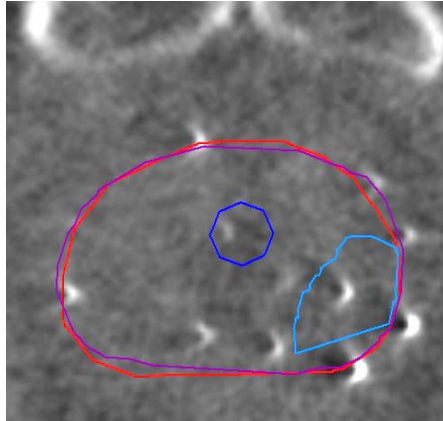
Boost₁ (light blue) is cut off after MRI–CBCT registration of patient 7. Prostate_{MRI} (purple) and US based prostate (red) and urethra (dark blue) contours can be seen as well.
